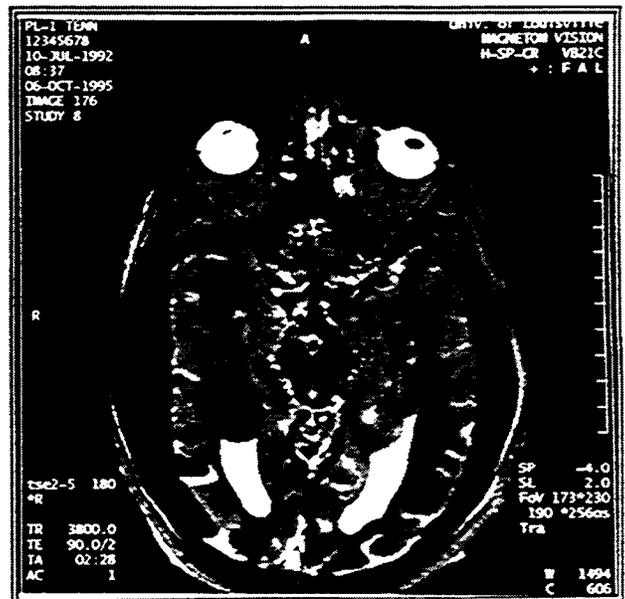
T2 Weighted MRI of a Head
